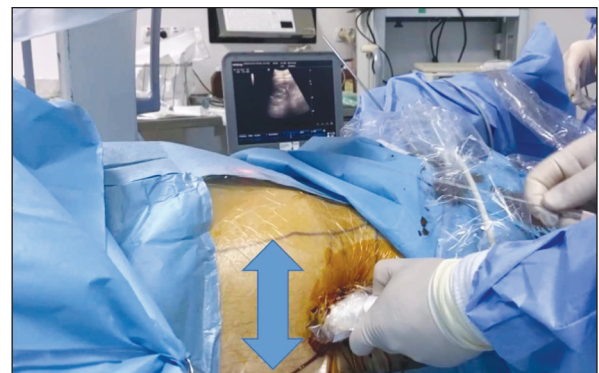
The widest view of the calyx to be accessed in the horizontal plane was stabilized using ultrasound.
